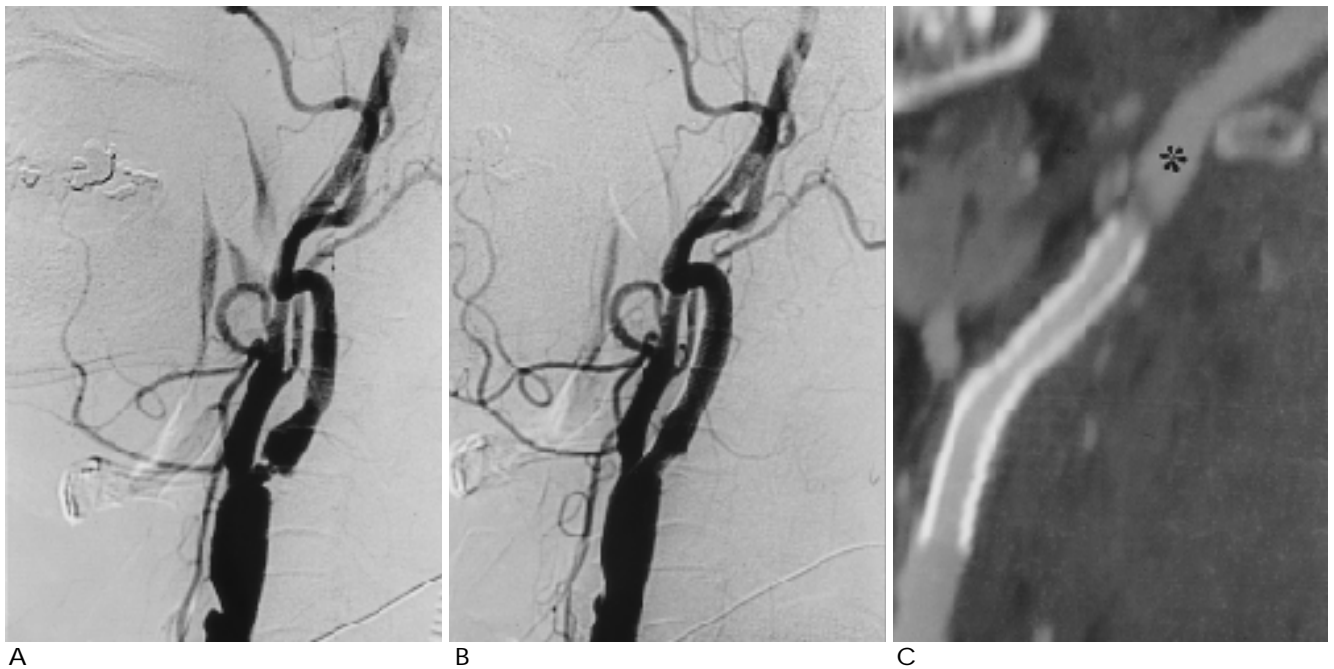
Comparison of conventional angiography and CT angiography in stent-implanted left common and internal carotid artery in a 61-year-old man (Case 1)
